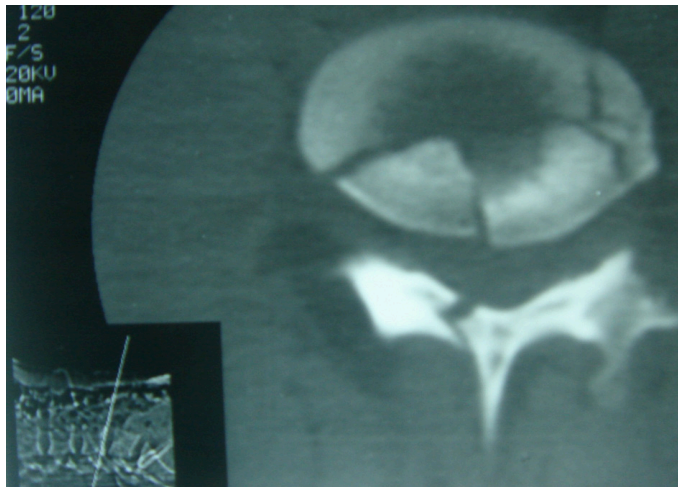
A case from our cohort: A 25-year-old male patient was brought to the emergency room with both legs paralyzed after a traffic accident. In addition to instrumentation and fusion procedures, this patient underwent L4 total laminectomy and primary dural repair. Postoperative ASIA score increased from C to D. Lumbar CT axial image demonstrate L4 burst fracture
